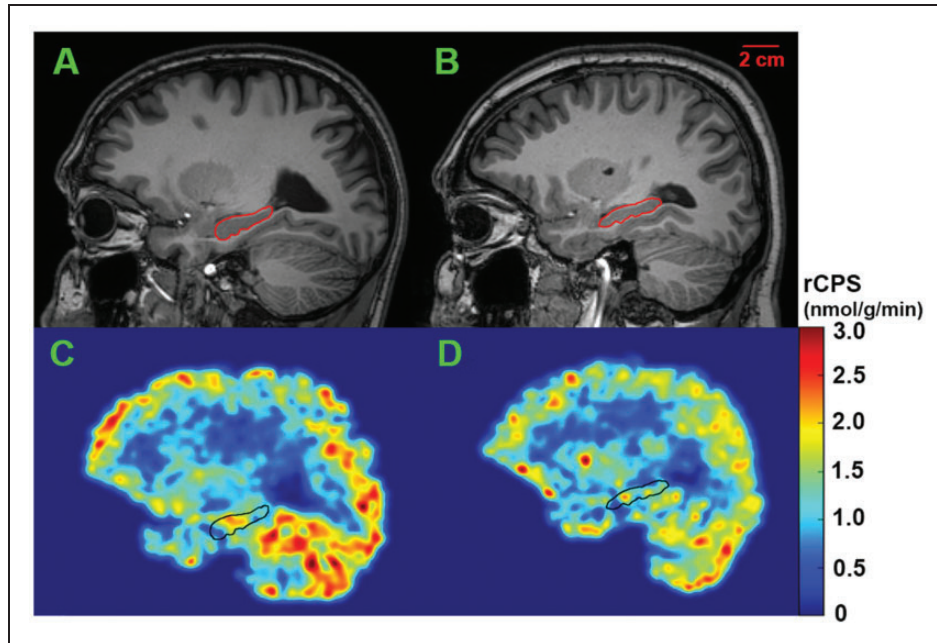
Representative parametric images of rCPS at the level of the hippocampus in awake subjects. Magnetic resonance images (upper row) from a healthy control (A) and a subject with FXS (B) correspond to rCPS images shown below (C, D, respectively). Parametric rCPS images were smoothed with a 3D Gaussian filter (kernel 4 mm full-width-at half-maximum) and color-coded for rCPS (colorbar on the right). Images are in the sagittal plane. Scalebar on upper right in B applies to all four images. We assumed a tissue density of 1.0 g/mL. Outlines of the hippocampus are shown on all images.
